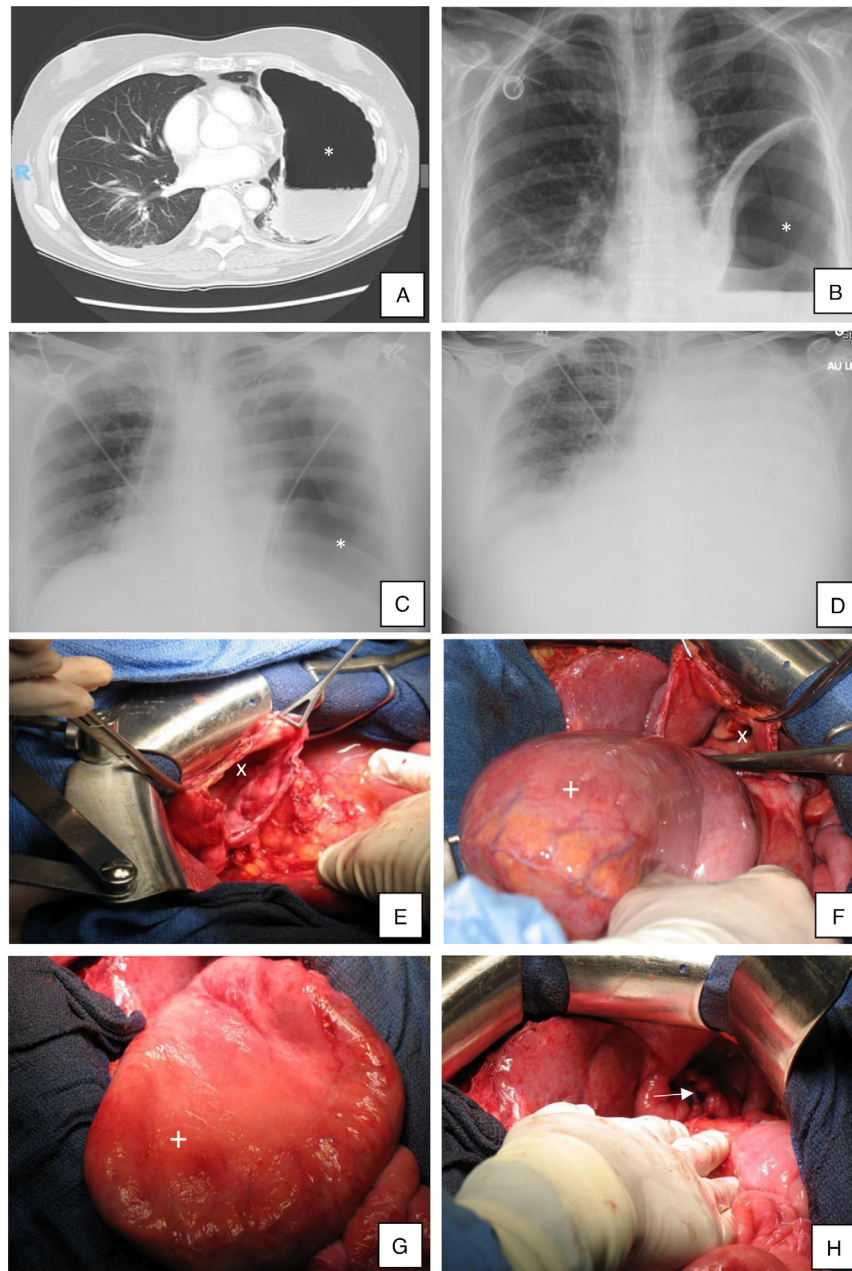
Preoperative imaging. (A) Computed tomography scan of the patient (day 1, at onset of sub-occlusive symptoms). (B) Chest X-ray of the patient (day 1, at onset of sub-occlusive symptoms). (C) Chest X-ray of the patient (day 4, with sub-occlusive symptoms; day 1 of multiorgan failure and hypercapnic respiratory failure). (D) Chest X-ray of the patient (day 5, with sub-occlusive symptoms; day 2 of multiorgan failure and hypercapnic respiratory failure). Intraoperative images of the patient's hernia. (E) Lateral view of the hernia orifice. (F) Inferior view of the hernia orifice. (G) Stomach. (H) Inferior view of the hernia orifice suture. *, gastric bubble in thorax; x, diaphragmatic defect; +, stomach; →, Hernia orifice suture.
